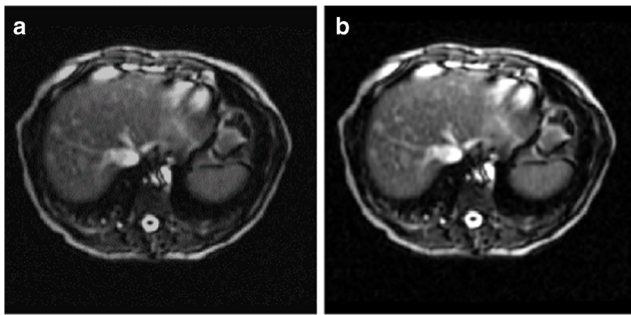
Image smoothing denoising processing. a The original MRI image of liver; b The MRI image of liver after pre-processing.
